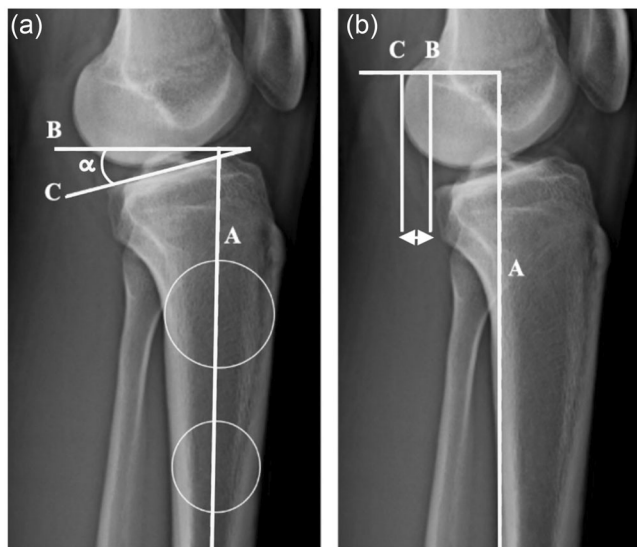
Radiographic assessment of sagittal-plane parameters on lateral knee radiographs. (a) Measurement of posterior tibial slope, defined as angle α between the medial tibial plateau and the anatomical axis of the proximal tibia. (b) Measurement of static anterior tibial translation under monopodal weight-bearing conditions, defined as the horizontal distance between Points B and C [4, 7].
